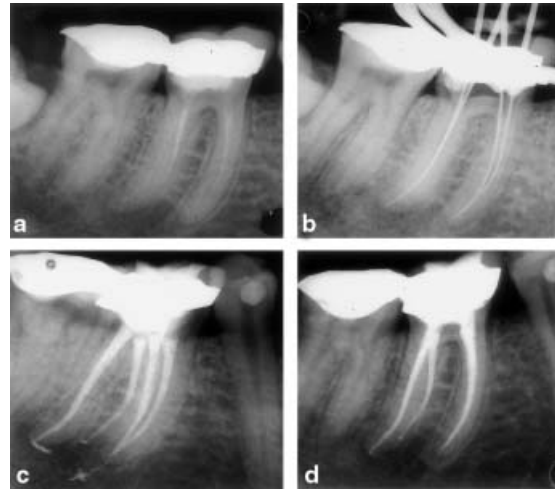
(a) Radiograph of tooth 46 restored with a ceramic-metal crown and inadequate root fillings, despite symptoms of swelling in the buccal fold and sensitivity to percussion and palpation there are no signs of apical radiolucencies. (b) Length-determination radiograph of the conventional root canals (one distal root canal and two mesial canals) and the root canal of the radix entomolaris. (c) Radiographic control following definite obturation of the four root canals. (d) One-year postoperative radiographic control indicating healthy apical bone structure with no radiographic signs of apical periodontitis.
